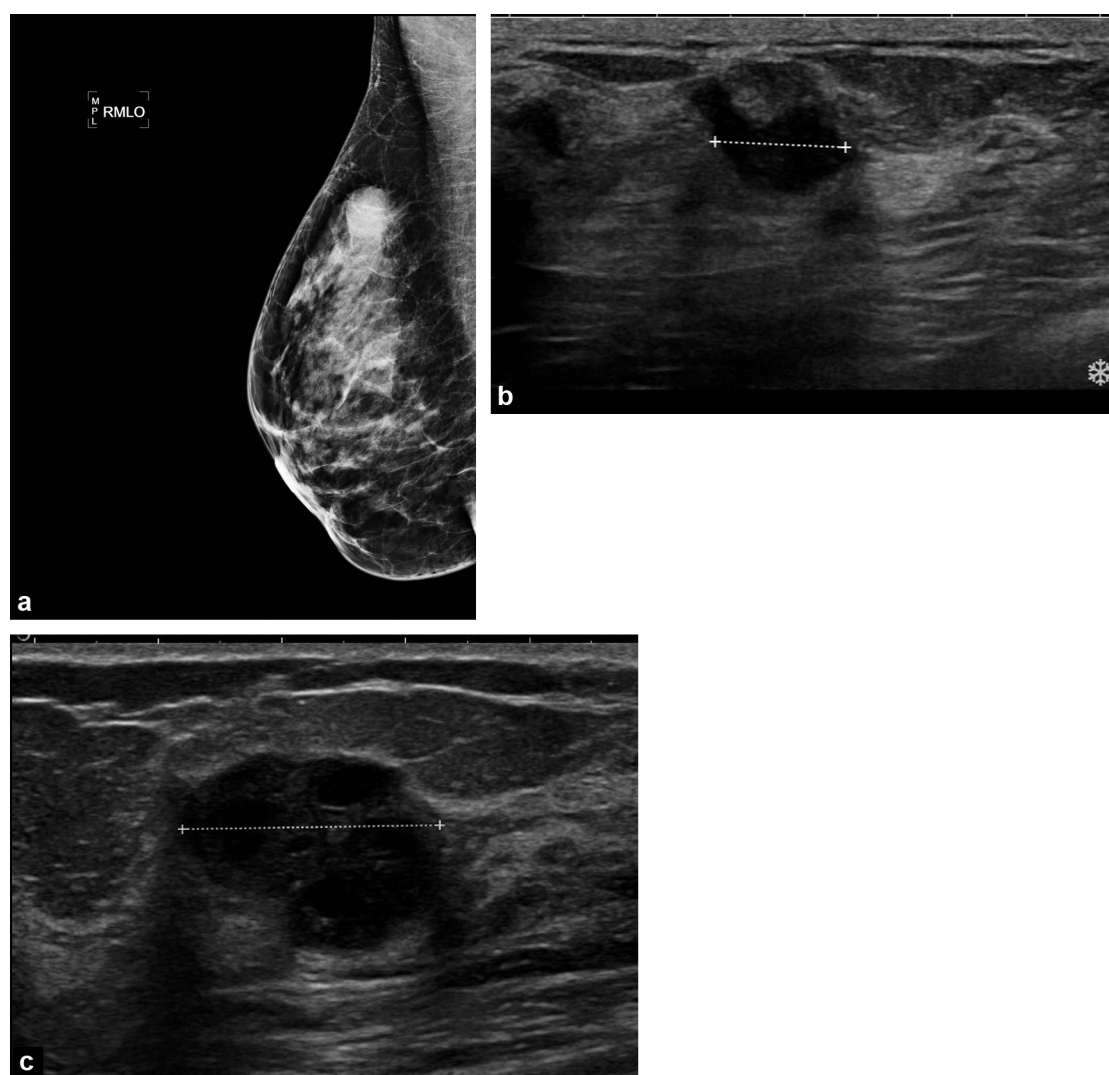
Triple-negative sub-types. a: forty-eight years. Mammogram: round mass at the union of the upper quadrants. Infiltrating ductal carcinoma grade III, oestrogen receptors/progesterone receptors– HER–: conservative treatment, adjuvant chemotherapy. b: fifty-one years. Sonogram: very hypoechogenic 10 mm mass with a circumscribed edge, non vascularized, pseudo-cystic, ACR 4. Infiltrating zf carcinoma grade II, oestrogen receptors/progesterone receptors– HER–. c: forty-two years. Sonogram: 18 mm, oval, very hypoechogenic mass with a circumscribed edge, abrupt interface, with posterior enhancement, ACR4. Infiltrating ductal carcinoma grade III, oestrogen receptors/progesterone receptors– HER–.
